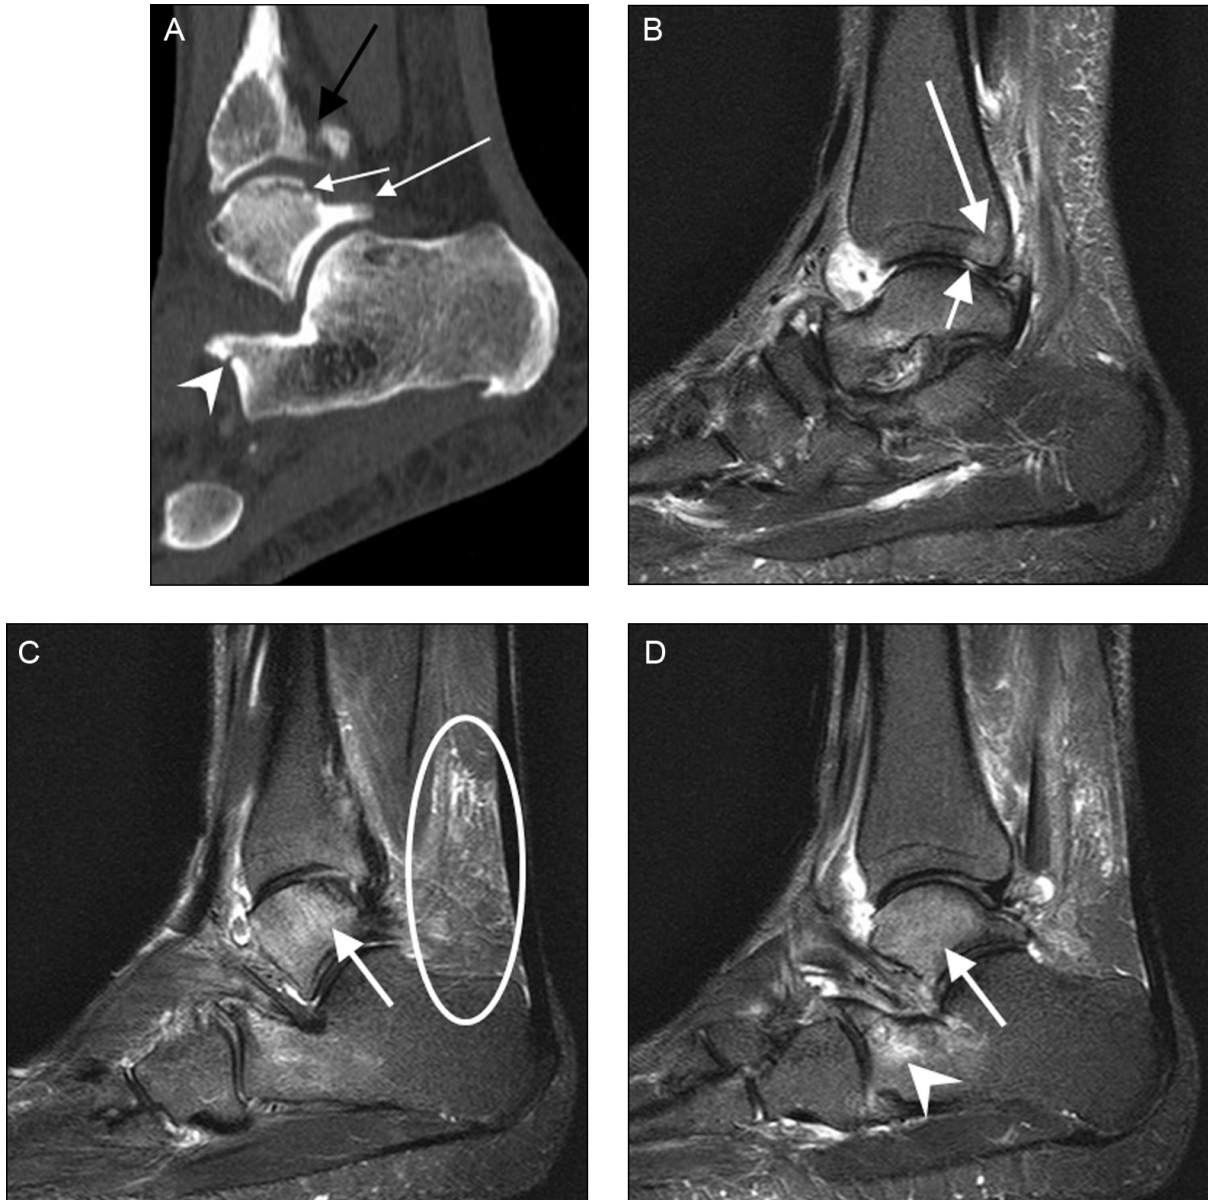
A 28-year-old male football player. (A) Sagittal reformatted CT image of the ankle shows an intra-articular fracture (short white arrow) adjacent to the Stieda's process (long white arrow) associated with non-displaced fracture of the anterior process of the calcaneus (arrowhead) and distal fibula (black arrow). (B–D) Sagittal proton density-weighted fat-suppressed MRI demonstrates the osteochondral nature of the posterolateral fracture of the talus with large bone marrow oedema of the talus (white arrow, C and D). There is a posterior focal cartilage defect of the tibia (short white arrow, B) with subchondral bone marrow oedema (long white arrow, C). There is a Kager's fat pad synovitis (oval). The oedema in the calcaneal bone (arrowhead, D) is secondary to a small fracture that is shown on the CT (arrowhead, A).
